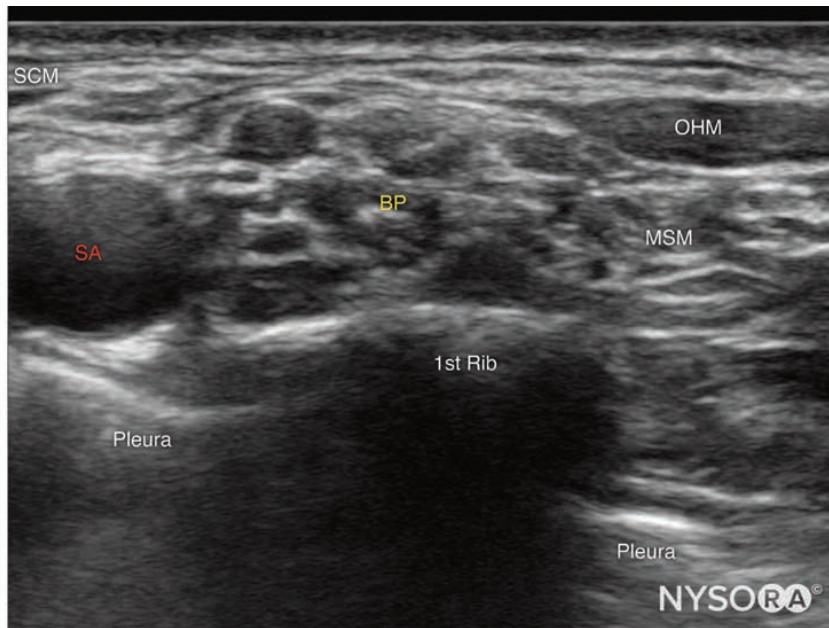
Transducer position at the supraclavicular fossa and ultrasound image obtained at this level. SCM, sternocleidomastoid muscle; SA, subclavian artery; BP, brachial plexus; OHM, omohyoid muscle; MSM, middle scalene muscle.
